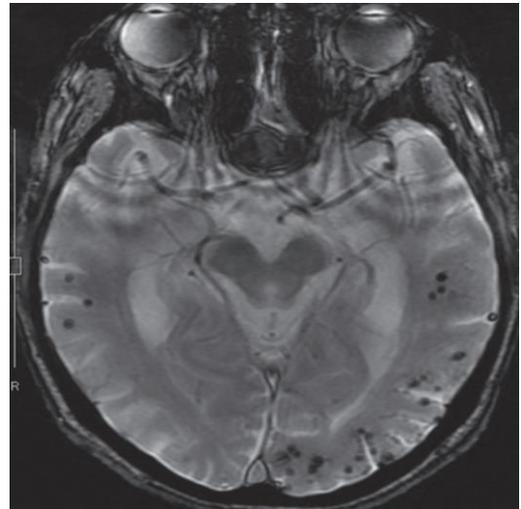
Typical neuroimaging findings of cerebral amyloid angiopathy. (A) Recent and old lobar macrohemorrhages in the frontal lobes on brain computed tomography. (B) Cortical microhemorrhages with lobar distribution and (C) focal subarachnoid hemorrhages (superficial siderosis) on gradient echo T2*-weighted brain magnetic resonance imaging. (D) Posterior distribution of white matter hyperintensities (arrows) on T2-weighted brain magnetic resonance imaging (Yamada, 2015).
